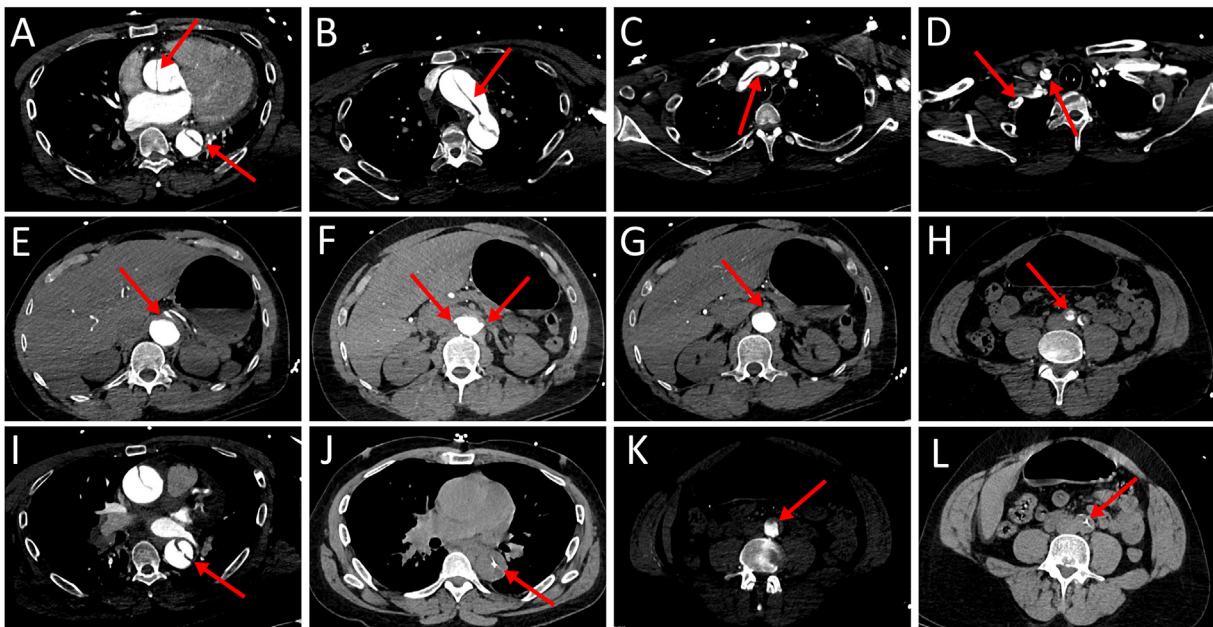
Computed Tomography Angiography demonstrating extensive Type A aortic dissection extending from the sinus of Valsalva to the common iliac arteries with involvement of the ascending (A) and arch of the aorta (B), subclavian artery (C), right common carotid and right subclavian arteries (D), celiac artery (E), bilateral renal arteries (F), superior mesenteric artery with complete thrombosis (G), and common iliac arteries (H). Comparison of the Computed Tomography Angiography and non-contrast studies demonstrates evidence of dissection at the same level, highlighting pertinent non-contrast imaging findings corresponding to the respective contrasted studies at the level of the descending thoracic aorta (I, J) and distal abdominal aorta (K, L).
